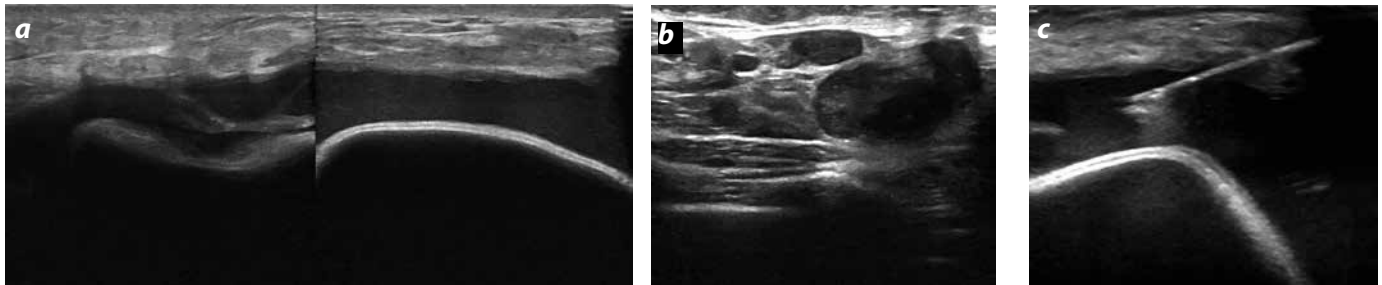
Post-surgical collection ultrasound in right breast. a) Shows a peri-implant collection with low-level echoes. b) Right axillary lymphadenopathies. c) Percutaneous drainage guided by ultrasound. Cultures showed infection by *Mycobacterium Abscessus*.
